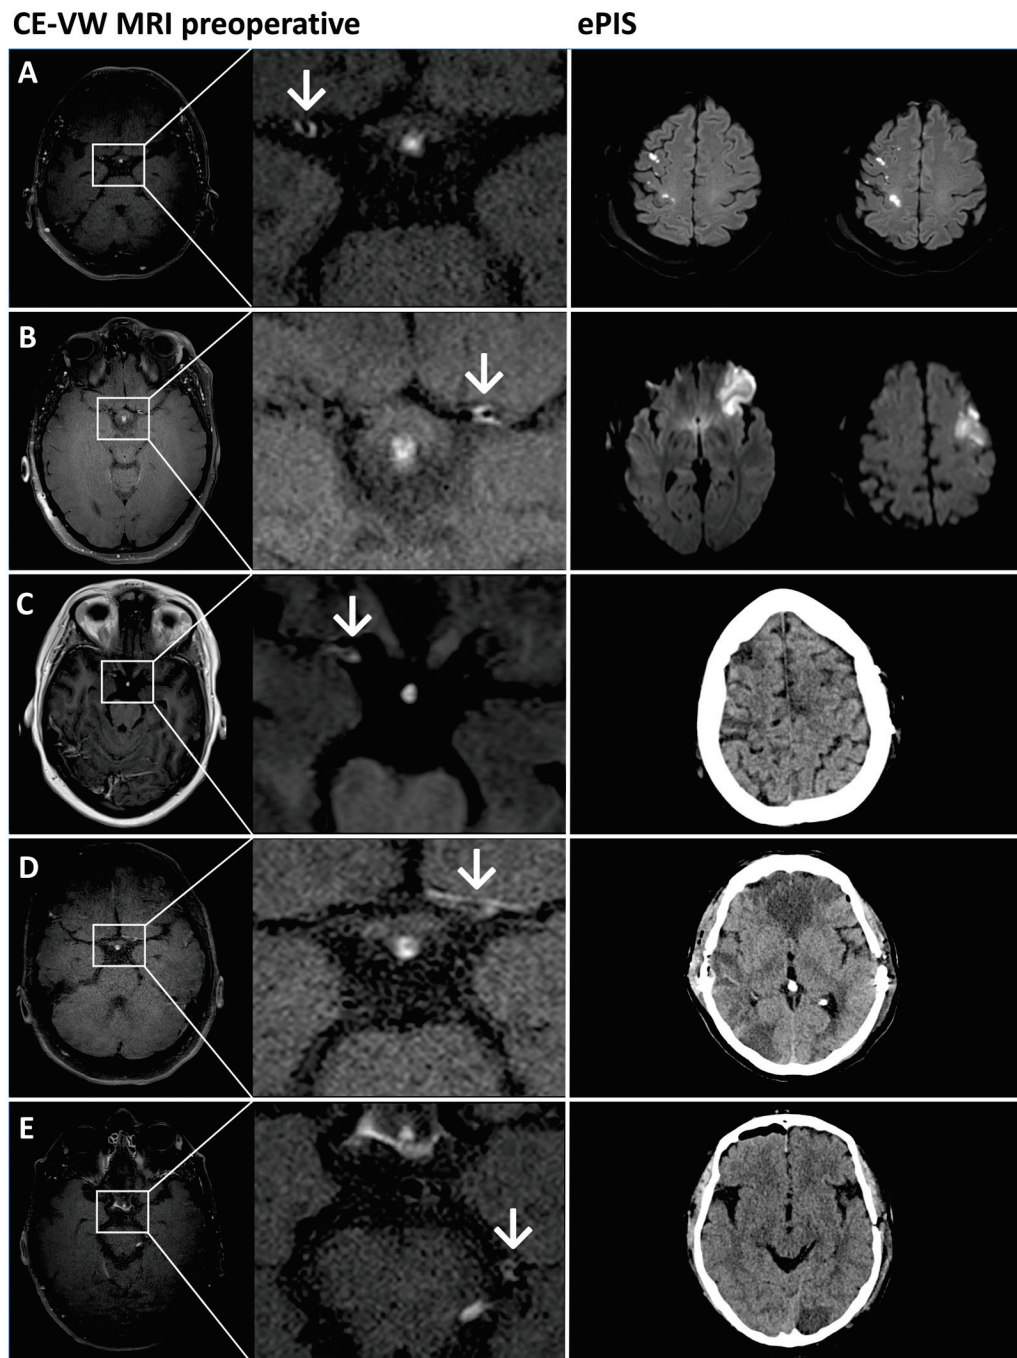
Imaging of five patients (A–E) who had a PAIS. Left column: preoperative VW-CE imaging (MRI). White arrows mark a VW-CE (exemplary slices). Right column: postoperative imaging to visualize a PAIS. The first two cases (A,B) received diffusion-weighted MRI sequences, while the other (C–E) received CT imaging. (A) Ischemia in the MCA and ACA/MCA watershed area with bilateral ACA supply via the right ICA (Figure 2A), which is possibly hemodynamically induced. (B) The initial situation is analogous to that of case (A), with bilateral ACA supply via the left ICA. However, in this instance, the infarcts are wedge-shaped, which may be indicative of a thromboembolic process. (C) Right frontal ischemia in preoperatively advanced ICA stenosis on both sides. (D) Territorial infarcts of the ACA on both sides and parietooccipital with ACA supply on both sides via the left ICA, corresponding to VW-CE, which is most likely hemodynamically caused by intraoperative blood pressure fluctuations. (E) Occipital ischemia on the left and collaterals (Figure 2E) via the left ICA with VW-CE at the P1/P2 transition.
